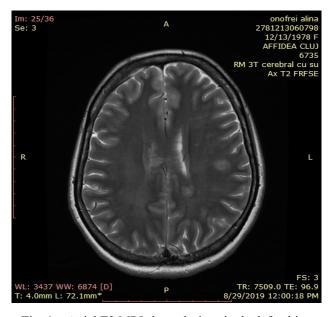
Axial T2 MRI shows lesions in the left white matter.
